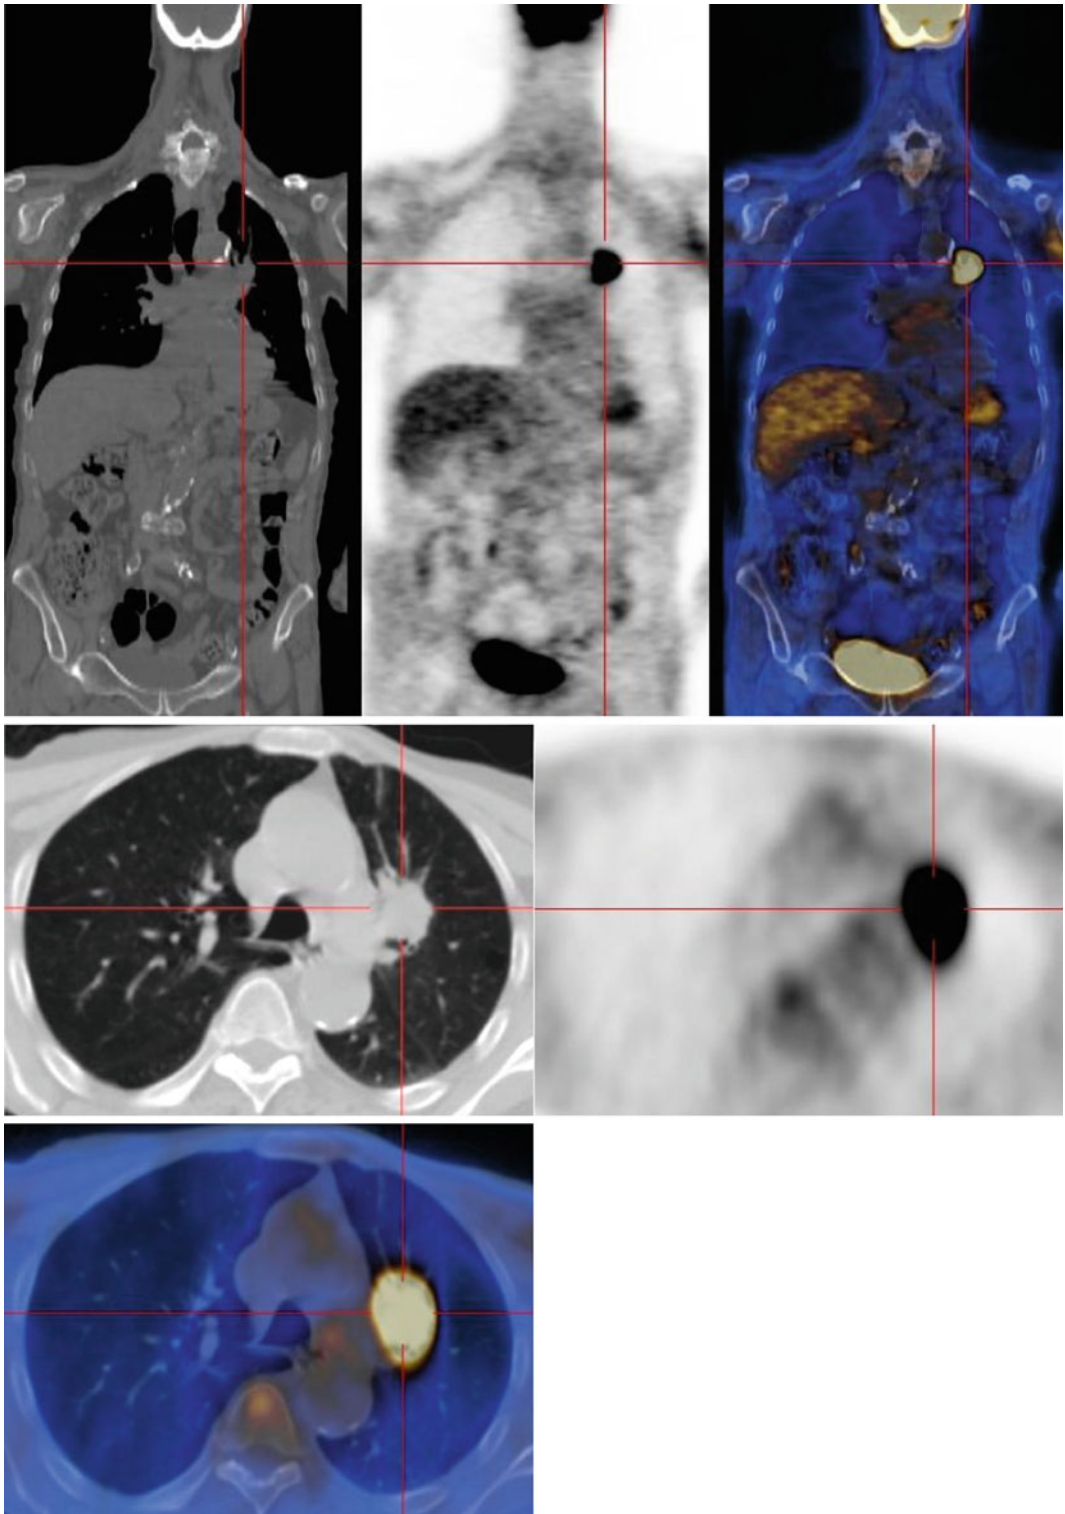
CT-PET: at the lingula, a solid speculated mass with irregular margins, indistinguishable from the hilum, which has intense carbohydrate consumption
